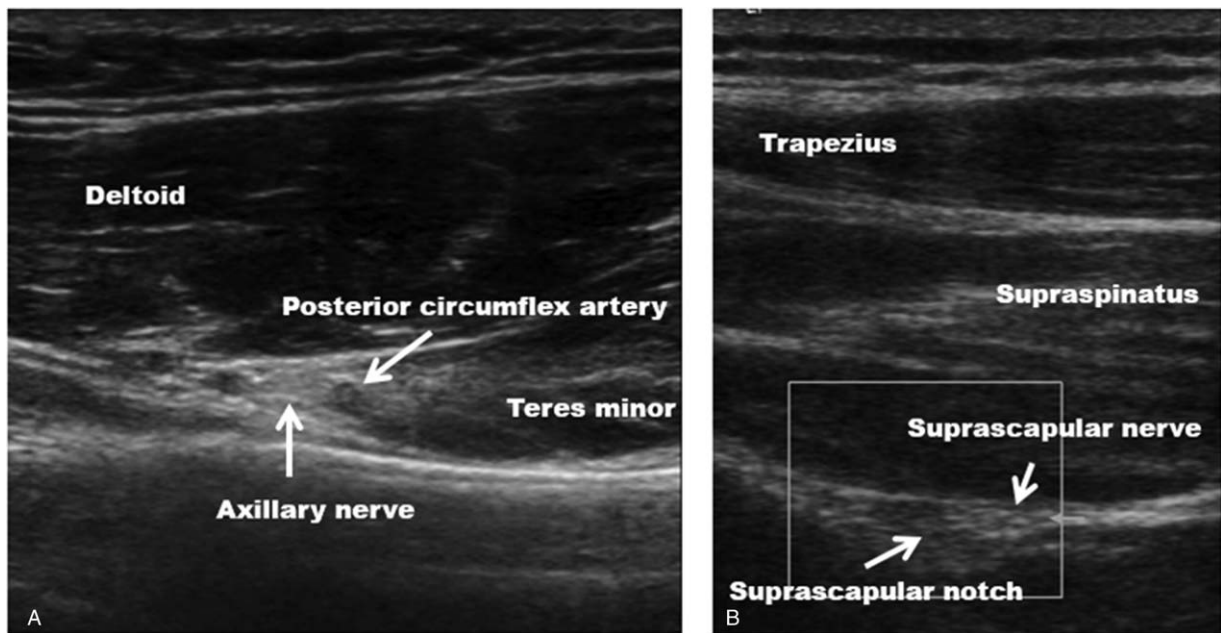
Ultrasound-guided images. (A) The axillary nerve traveled through the quadrangular space, with the posterior circumflex artery innervating deltoid and teres minor muscles. (B) The suprascapular nerve passed through the suprascapular notch beneath supraspinatus, innervating the supraspinatus muscle.
